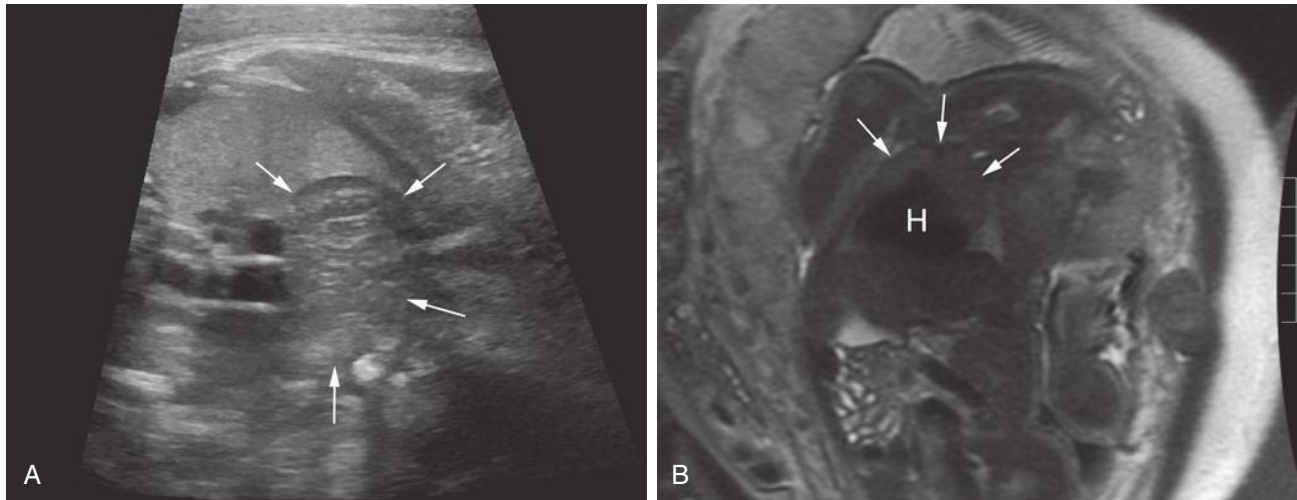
Normal thymus. A, The normal thymus (*arrows*) may appear quite prominent in a fetus. It is usually seen as an oval soft tissue structure anterior to the great vessels, as in this case. It should not be misinterpreted as a chest mass. B, A magnetic resonance imaging scan of the same patient demonstrates the normal thymus (*arrows*). H, heart.
